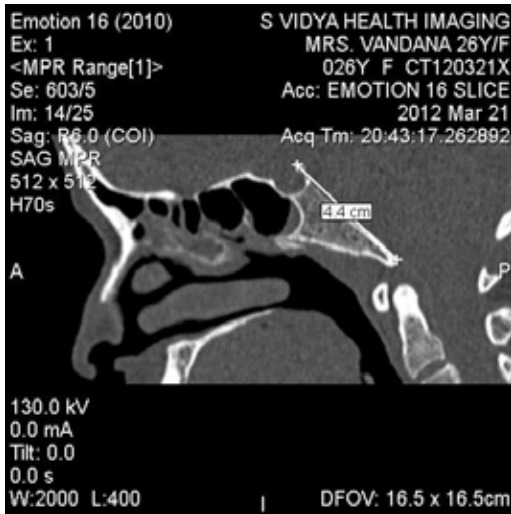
Showing measurement of Clivus length in a Sagittal view of an adult CT.
